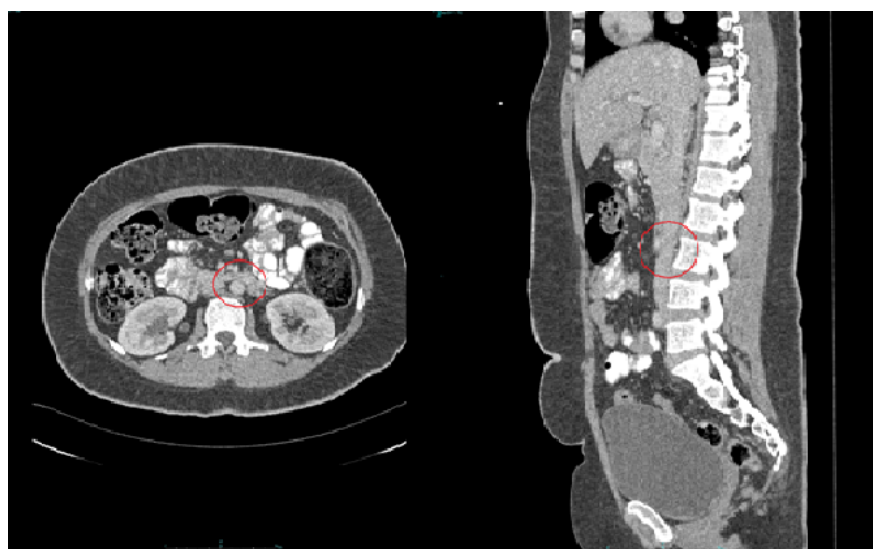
Follow up CT abdomen with contrast (a) axial and (c) sagittal view shows complete resolution of the previously seen abdominal aorta thrombus in the circled area at the level of L3 vertebrae.
